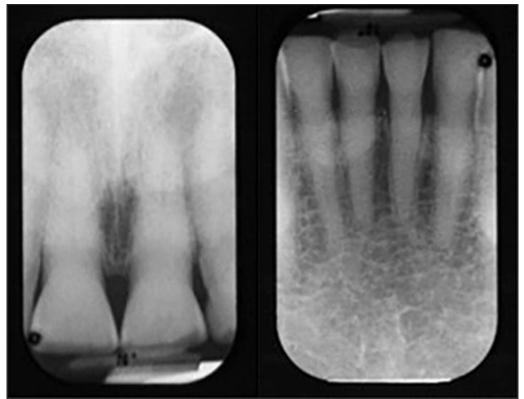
and 68B. Periapical radiographs showing secondary dentin deposition in maxillary (A) and mandibular (B) anterior teeth most likely due to attrition.
